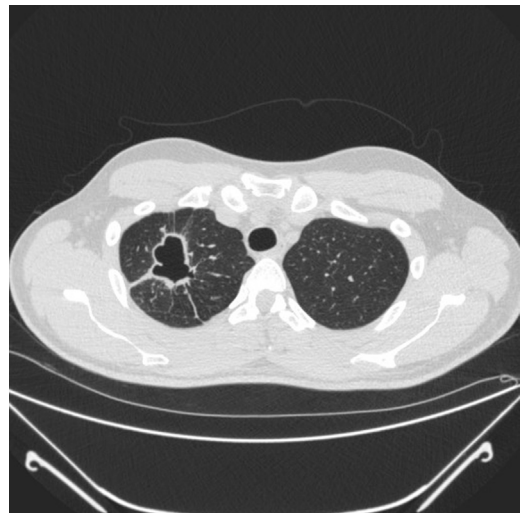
Axial chest CT demonstrates a thick-walled upper lobe cavitary lesion in a 38-year-old man residing in Nashville, Tennessee. The patient underwent bronchoscopy with transbronchial biopsies with tissue cultures confirming the diagnosis of Blastomycosis.
